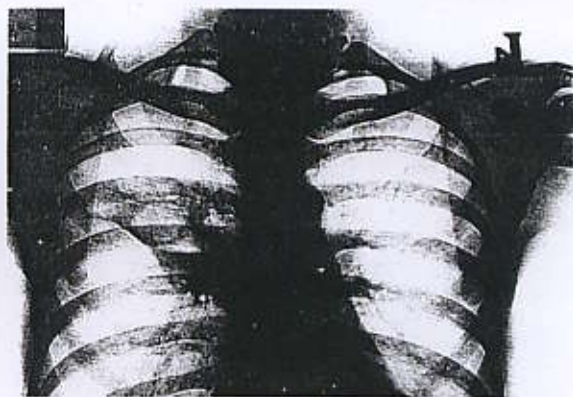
Chest radiograph showed the cavitary lesion with air fluid level in RUL infiltration.
